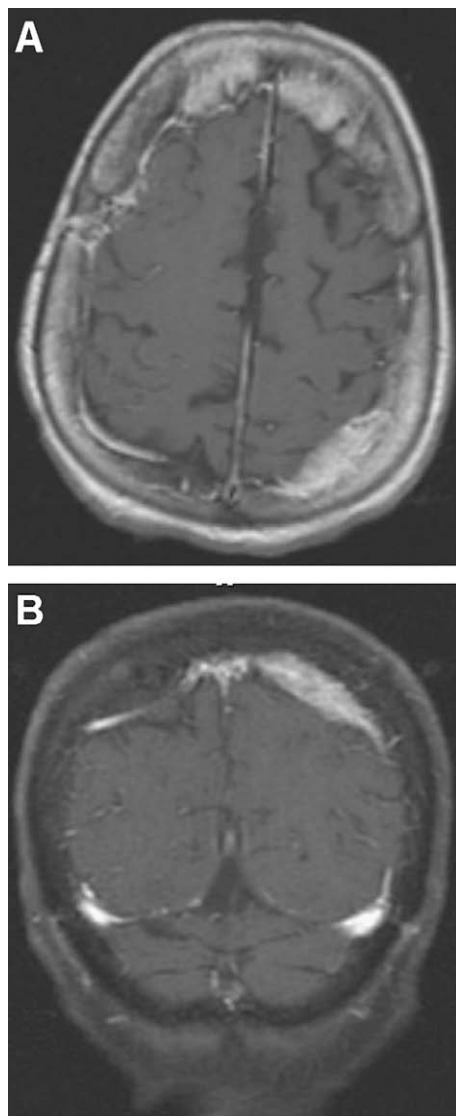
Two-month postoperative (A) axial and (B) coronal T1-weighted MRI with contrast enhancement showing significant reduction in size of the left parieto-occipital lesion.
